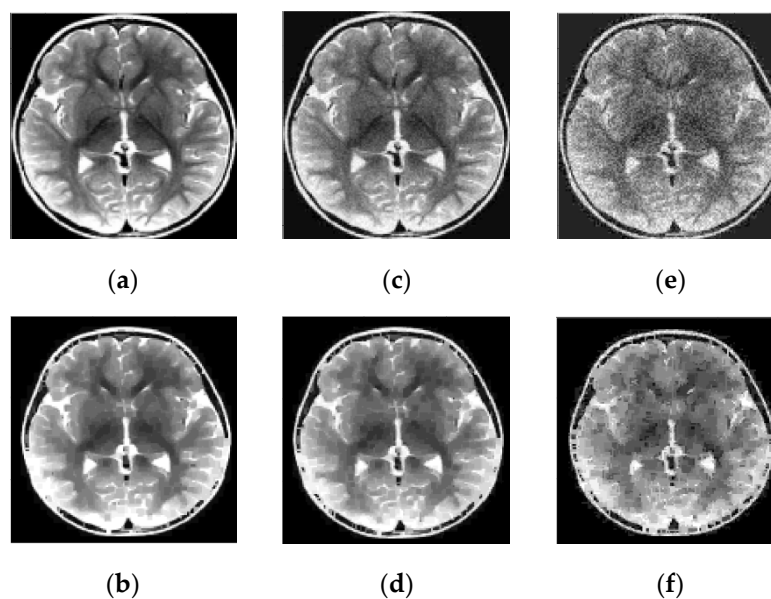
Results of reconstruction of MRI human brain image based on qualitative data. (a) Original image; (b) Reconstructed image; (c) Original low noise image; (d) Reconstructed low noise image; (e) Original noisy image; (f) Reconstructed noisy image.
